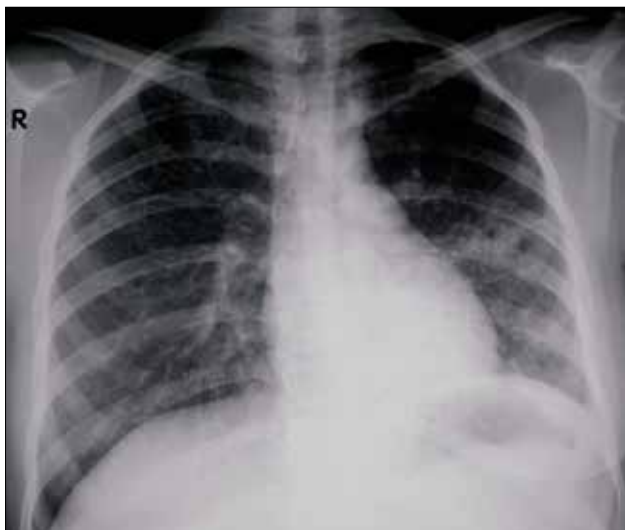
Chest radiograph at the time of diagnosis showing an airspace infiltrate in the lingula
